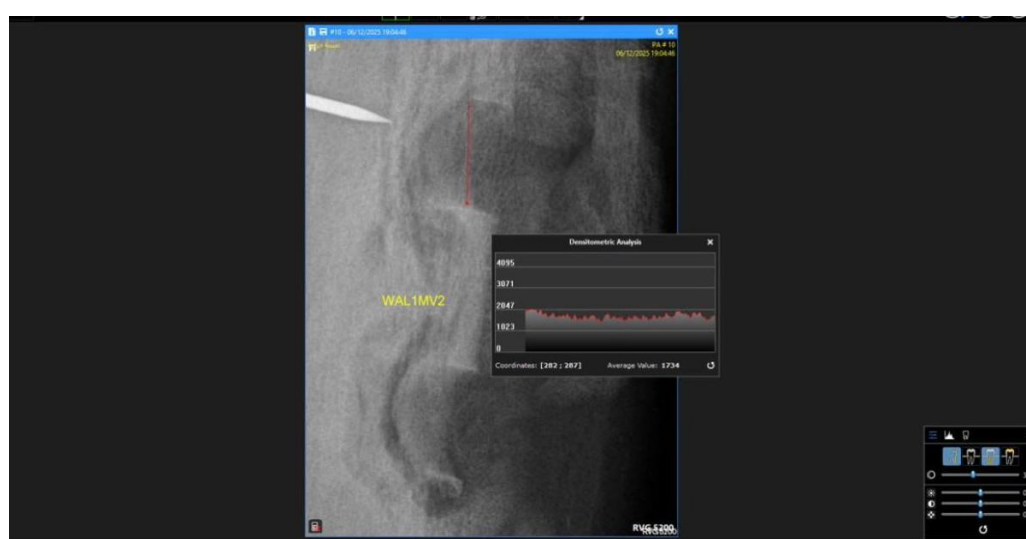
Radiographic densitometric screenshot labelled WAL1MV2, showing the measured region around the defect site with an average value of approximately 1734.
